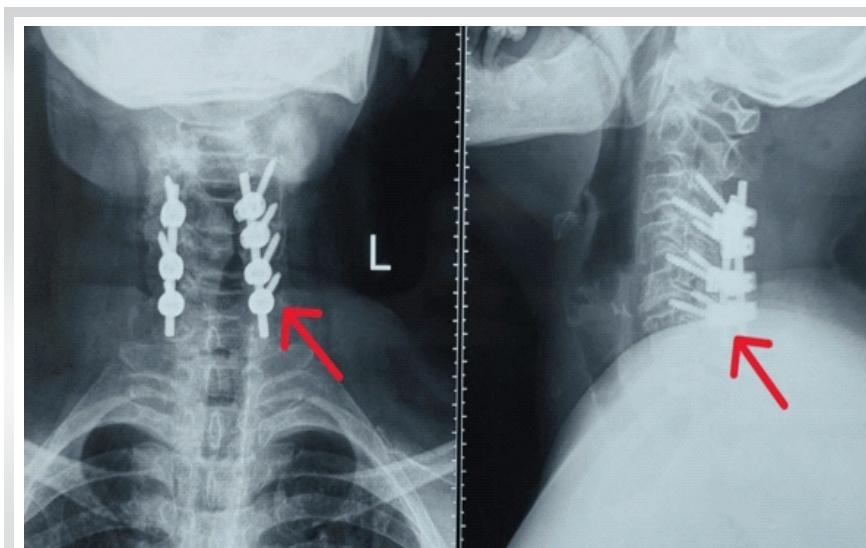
Postoperative radiographs following posterior cervical decompression and fusion. Postoperative anteroposterior and lateral radiographs demonstrating satisfactory C3–C7 lateral mass screw–rod fixation (arrows), maintained cervical alignment, and a stable posterior cervical fusion construct following posterior cervical decompression and fusion.
